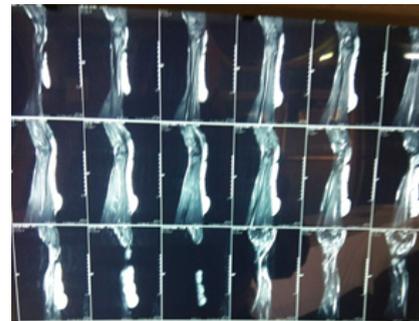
MRI Showing the Neurofibroma
